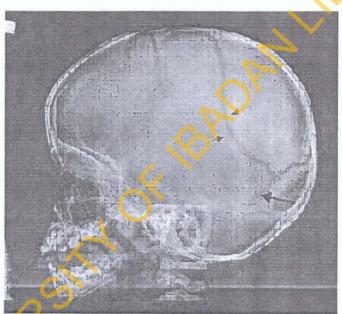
Lateral x-ray of the skull. Note the serrated lambdoid suture (arrow) in the occipital area, as opposed to the fracture lines (arrowheads).
